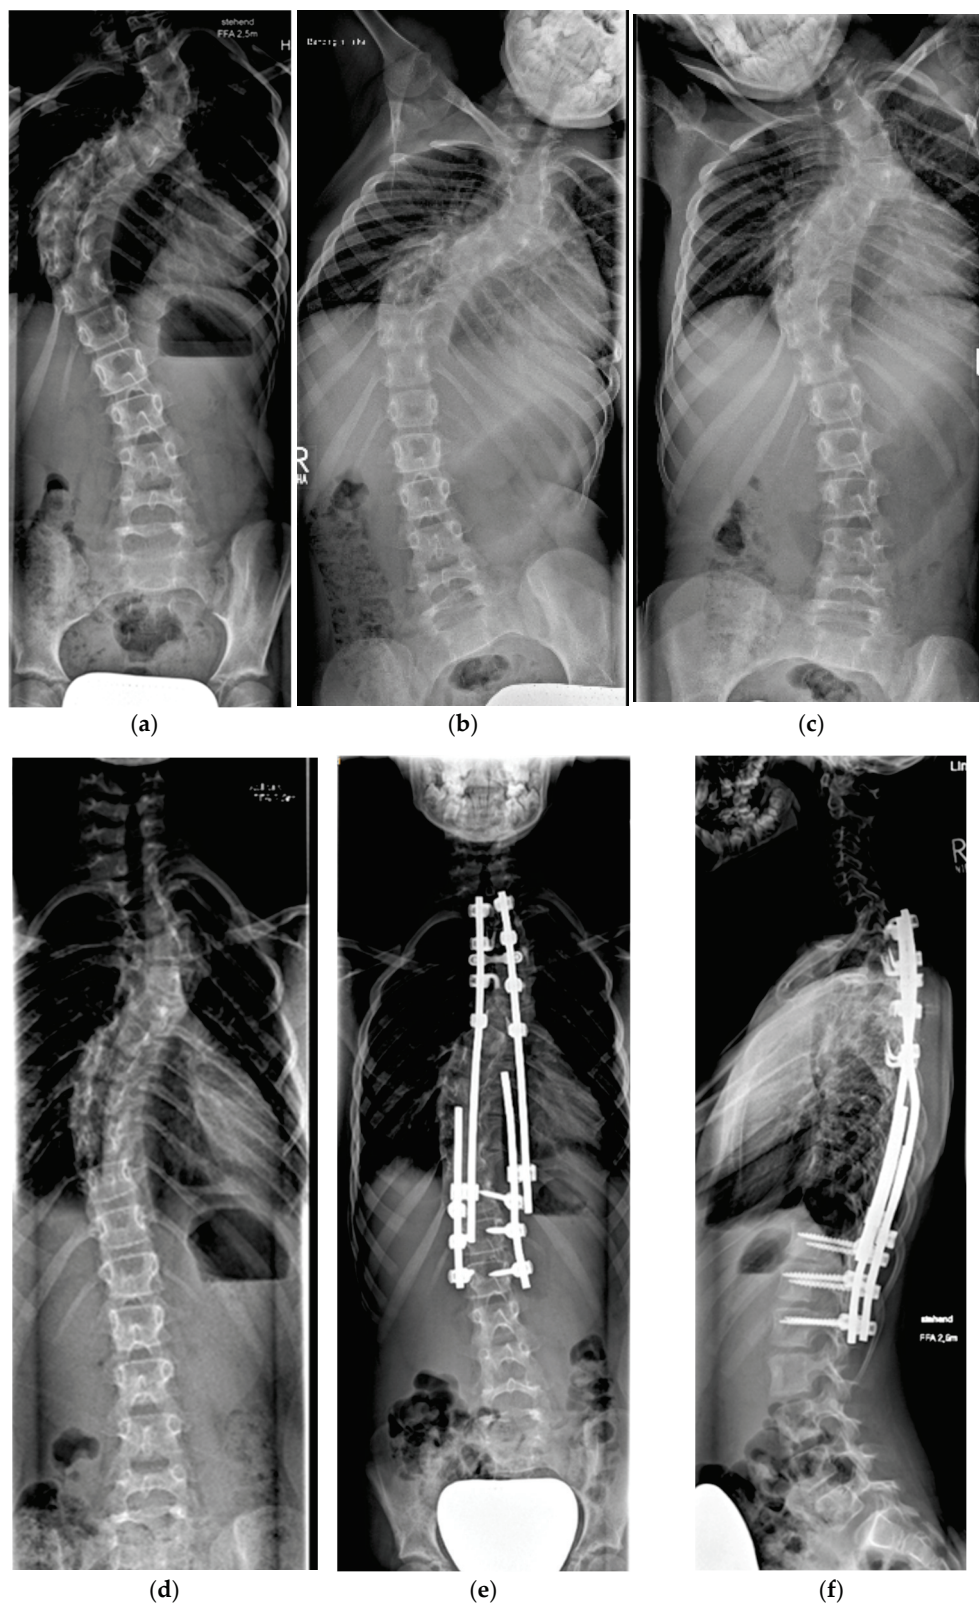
Nine-year-old patient with severe dystrophic scoliosis (a). Lateral bending radiographs showing curve rigidity (b,c). After 4 weeks of halo-gravity traction with excellent curve correction (d). After TGR application (e,f).
